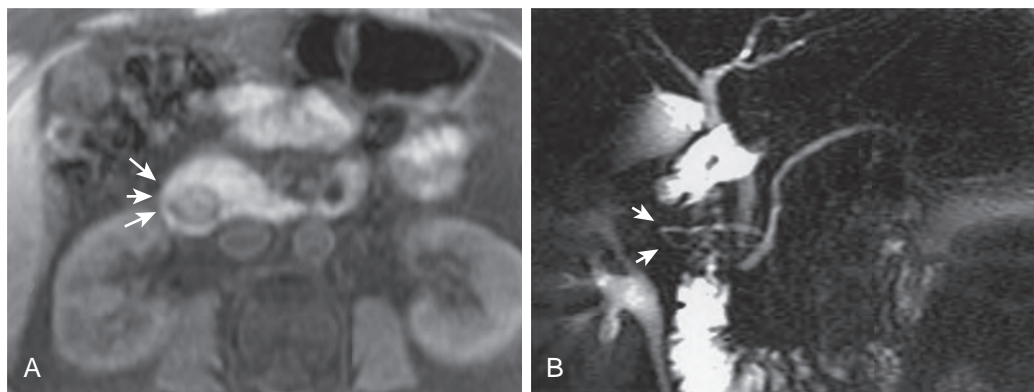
Annular pancreas: MR features. A. Axial fat saturation T1-weighted image shows the duodenum surrounded by pancreatic tissue (arrows). B. Coronal oblique thick-slab MRCP image demonstrates the duct of the annular pancreas (arrows) that forms a complete loop around the duodenum. This examination was performed after secretin administration. (Courtesy Dr. Carmen DeJuan, Department of Radiology Hospital Clinic, University of Barcelona, Spain.)
